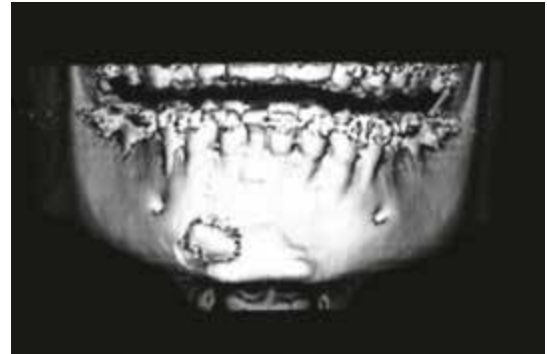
3D reconstruction from a mandible CBCT.
